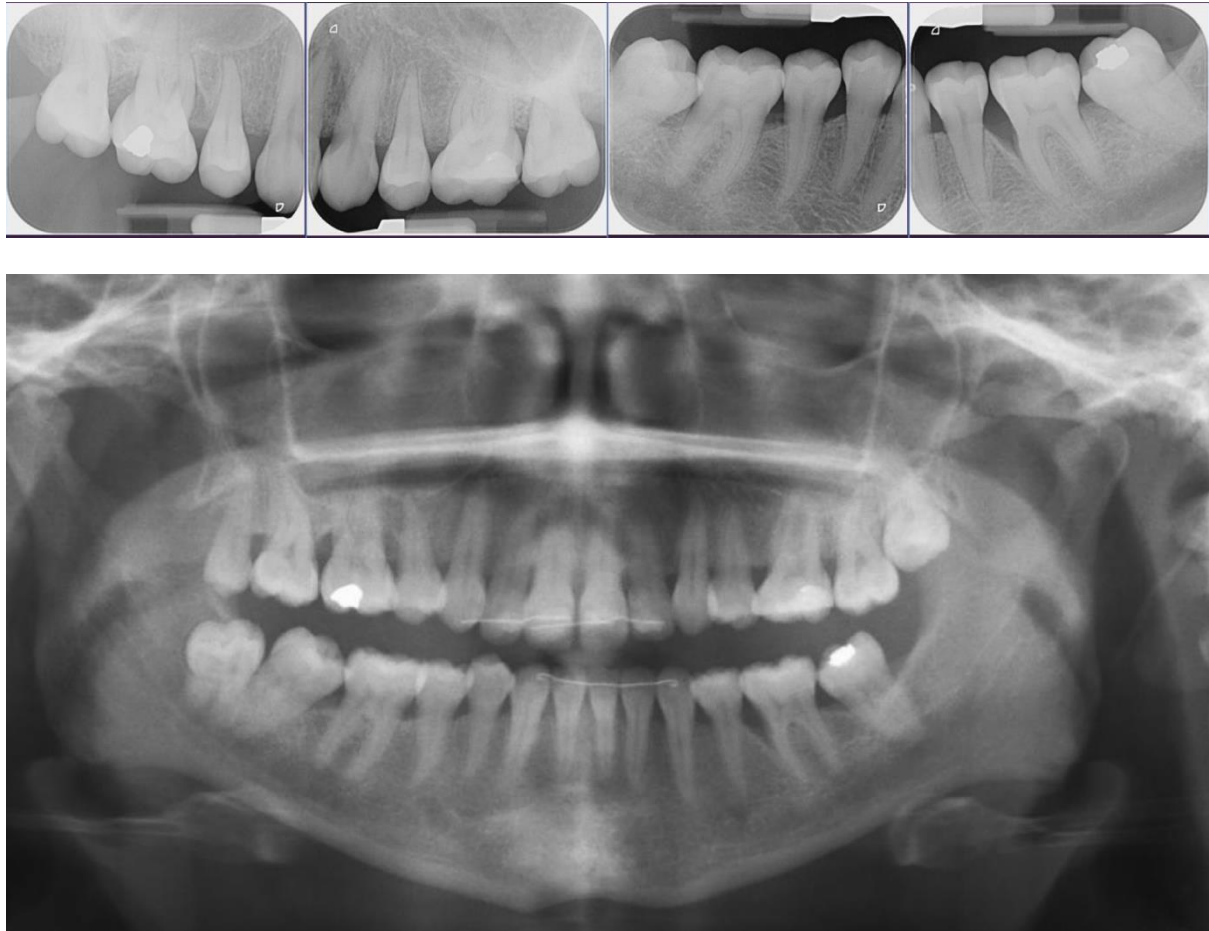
Radiographs – DPT & Periapicals
